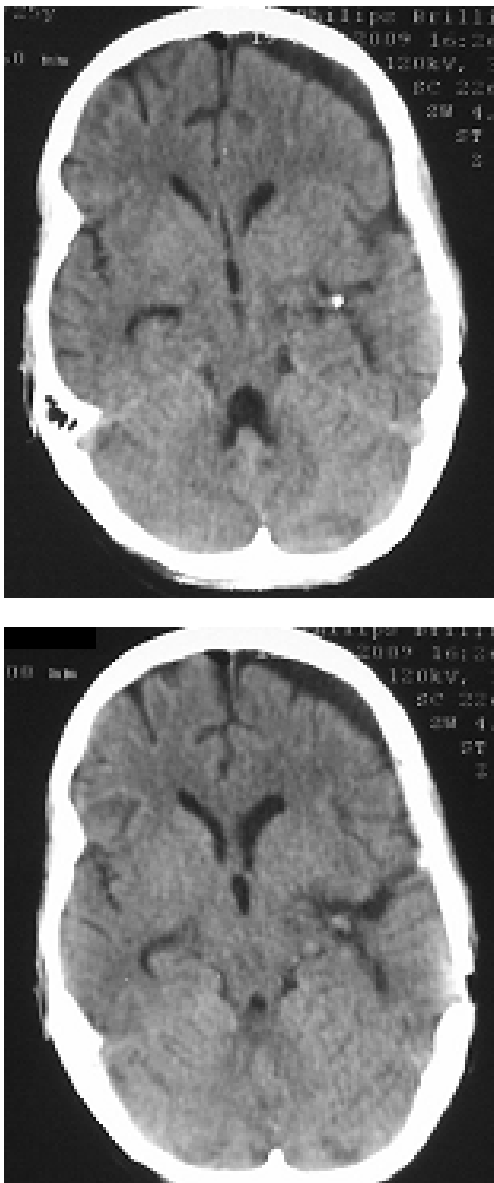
Cerebral CT scan, normal postoperative aspect
